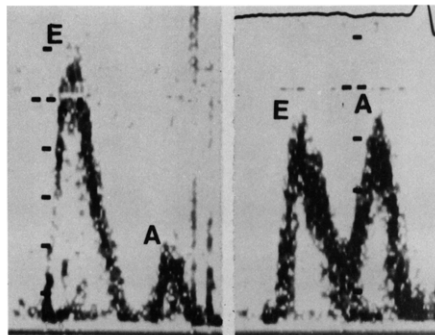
Doppler mitral flow patterns in a representative young (left panel) and old (right panel) normal subject. A = peak atrial filling velocity; E = peak early filling velocity.
